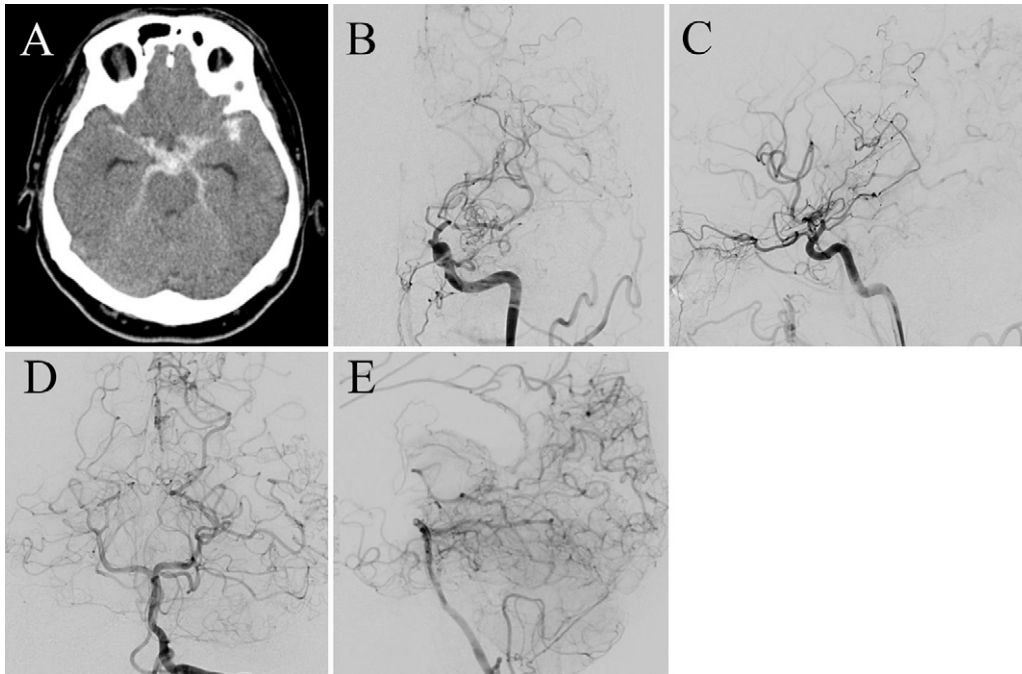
CT and DSA on admission. CT (A) shows diffuse SAH, slightly dense in the prepontine cistern. Left internal carotid angiography, anteroposterior (B) and lateral (C) views, shows severe left internal carotid artery stenosis and basal moyamoya vessels. Left vertebral angiography, anteroposterior (D) and lateral (E) views, shows collateral circulation from the posterior cerebral artery to anterior and middle cerebral arteries.
